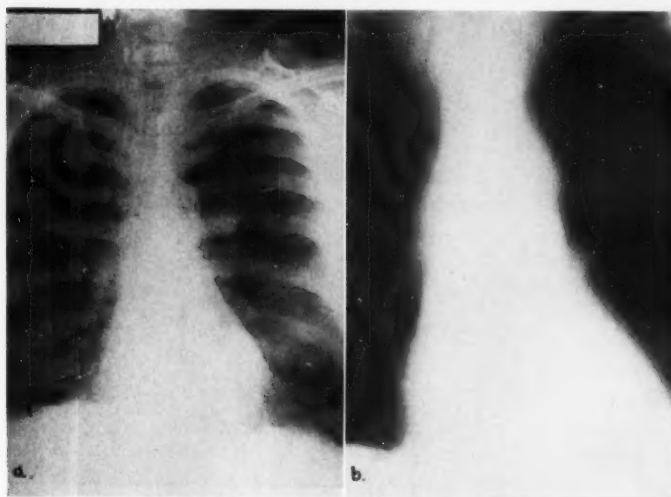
(a) Chest x-ray showing rounded density in left upper hilar and mid-lung field, and smaller rounded density in right lower lung field. (b) Laminographic film showing rounded density above the left hilum.
